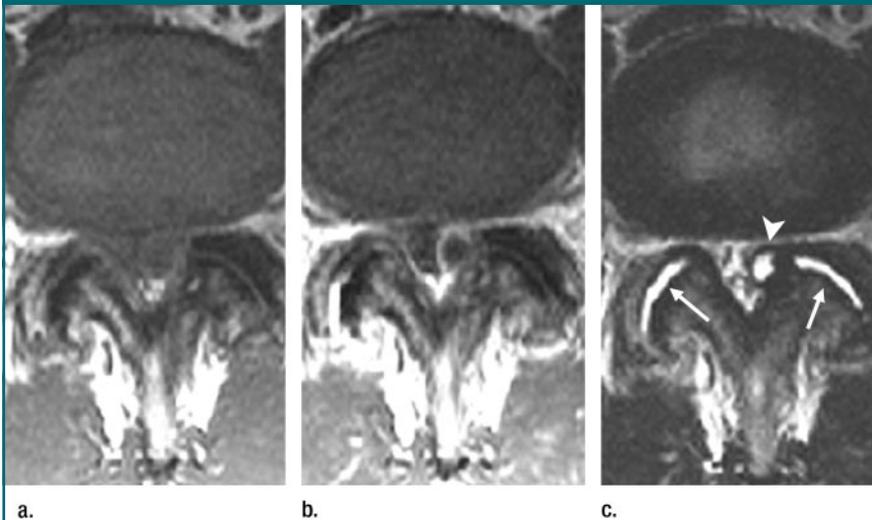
Degenerative synovial cyst. Transverse (a) T1-weighted SE (450/15), (b) T1-weighted contrast-enhanced SE (450/15), and (c) T2-weighted fast SE (4000/120) images through L4-5 disk space. Note severe bilateral degenerative facet changes and degenerative synovial cyst projecting medially from the left facet, causing central canal stenosis (arrowhead). There is distraction and fluid within degenerated facet joints (arrows).
